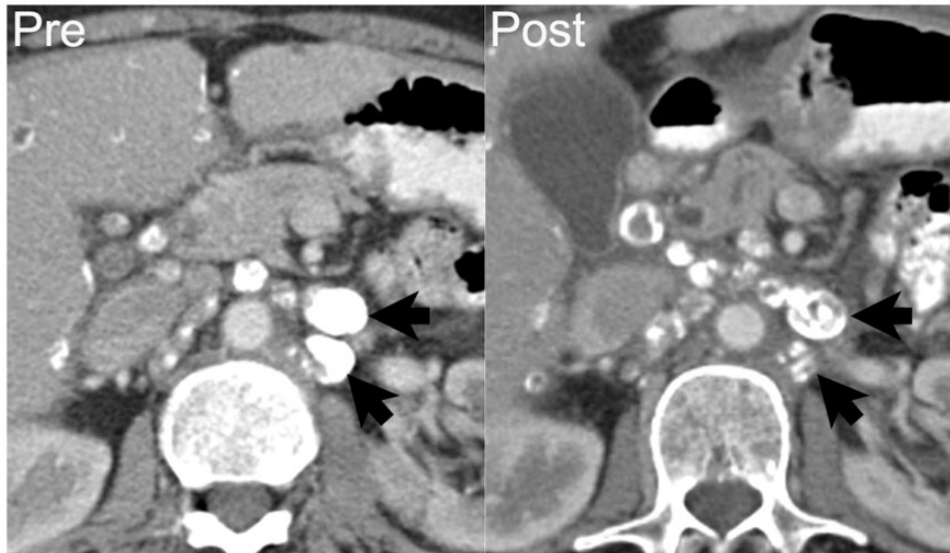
A 68-year-old woman with endometrioid cystadenocarcinoma of the ovary with metastases to the retroperitoneal lymph nodes. Axial contrast-enhanced CT shows densely calcified left para-aortic lymphadenopathy (arrows on left). After 8 months of chemotherapy, disease progressed with increasing soft tissue and decreasing calcification within the nodes (arrows on right). Over this period, CA125 increased from 1439 to 3838 units/ml.
